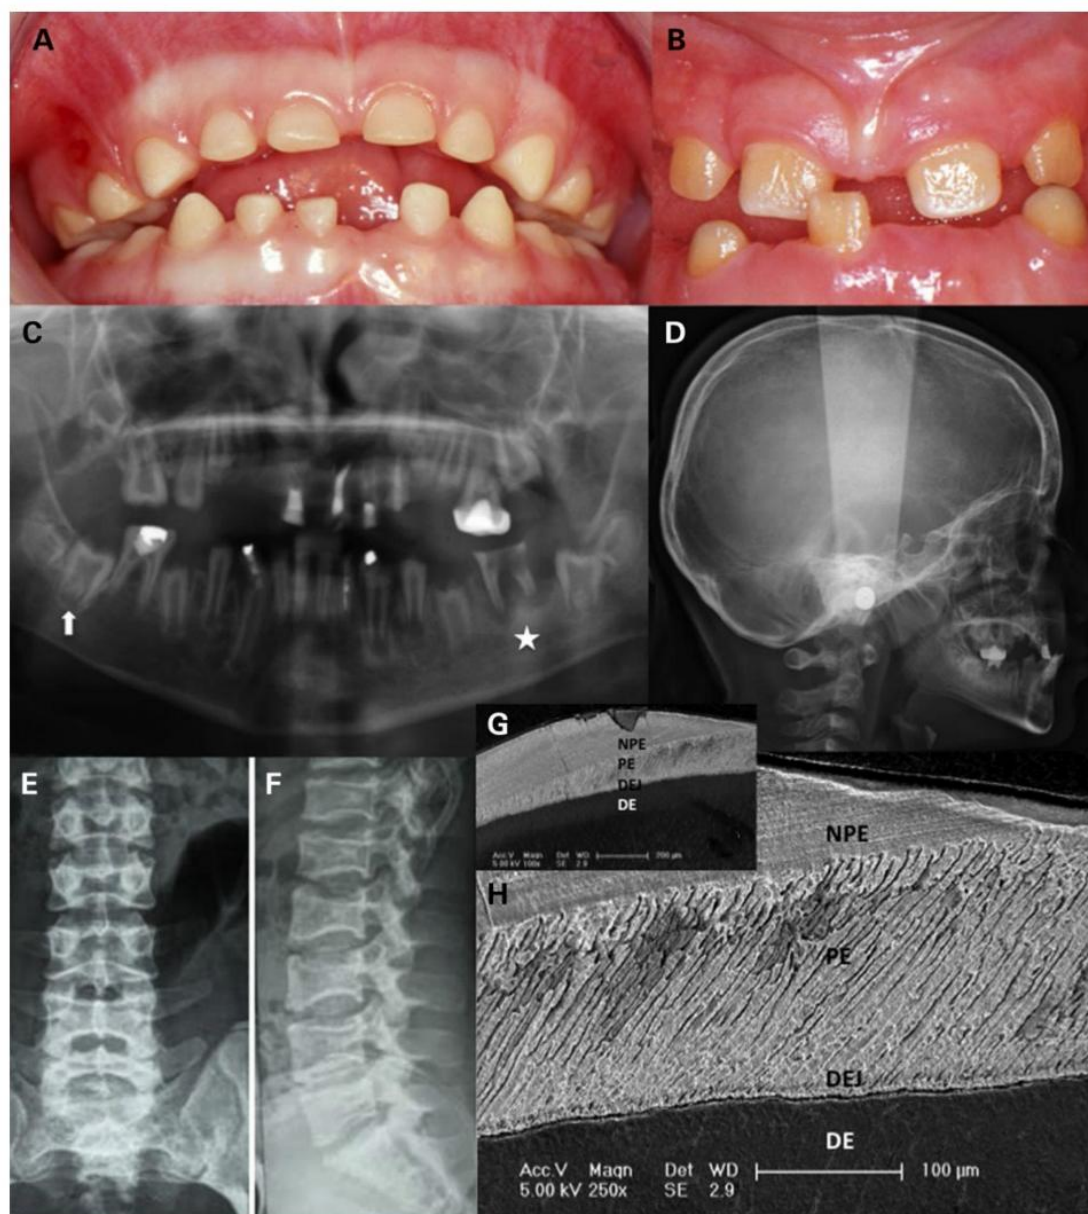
Phenotypic data on family 1. (A) Intraoral view of individual IV.1 (at age 5 years). All primary teeth are smaller and yellowish showing thin, almost absent, enamel. The dentition is spaced. (B) Intraoral view of individual IV.2 (at age 7 years). The erupting permanent incisors are yellow and small due to absent enamel. Primary teeth were lost after recurrent infections. (C) Panoramic radiograph of individual IV.2 (at age 9 years) showing erupted and non-erupted permanent teeth with no enamel. No teeth are missing. Pulp chambers appear large. Infection as a consequence of microbial contamination of pulp spaces is visible around the 36 (radiolucent area around the roots of the lower left first permanent molar filled star) in the absence of the protective enamel layer. The upward arrow points toward a second right lower permanent molar not yet erupted presenting with taurodontism and a large pulp chamber. (D–F) Radiographs taken from individual IV.2 (skull at age 9 years and spine at age 14 years). Skull radiograph reveals absent pneumatization of sinuses and mandibular prognathism secondary to underdevelopment of the maxilla. The spine radiographs show platyspondyly with indentations of both upper and lower vertebral endplates. (G) The enamel phenotype analyzed at the ultra-structural level through SEM revealed a thin PE layer directly starting at the dentino-enamel junction (DEJ). In some areas enamel formation continued as an aprismatic layer (NPE). Dentin (DE) was normal. (H) Close up of the PE and NPE thin layer.
